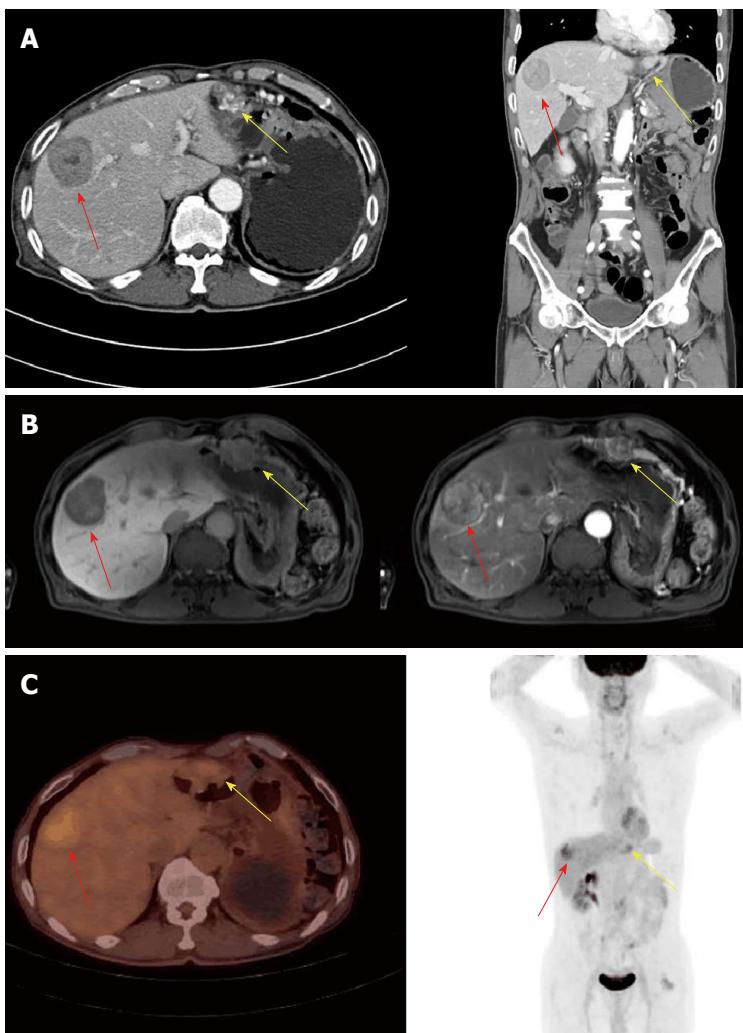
Diagnosis imaging of the patient. A: Computed tomography showed a 43 mm hypodense mass at S8 of the liver (red arrow) and a 23 mm sized hypervascular mass at the great curvature side of stomach (yellow arrow). B: Magnetic resonance imaging showed a well-defined encapsulated lesion (red arrow) in S8 of the liver, which showed a strong enhancement during the arterial dominant phase, with wash out during the delayed phase. The mass (red arrow) in the greater curvature of the stomach was accompanied by engorgement of the gastroepiploic vein. C: Fluorine-18 fluorodeoxyglucose positron emission tomography/computed tomography images showed a hyper-vascular mass at the great curvature side of stomach (yellow arrow) and a hypervascular metastatic mass at S8 of liver (red arrow).
